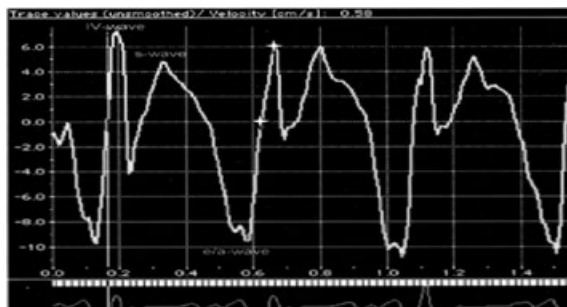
Right ventricular free wall isovolumic acceleration was measured using pulsed-wave tissue Doppler at the lateral tricuspid annulus. Difference between baseline and peak myocardial systolic velocities divided by the time interval from onset of the myocardial velocity during isovolumic contraction to the time at peak velocity of the wave.
